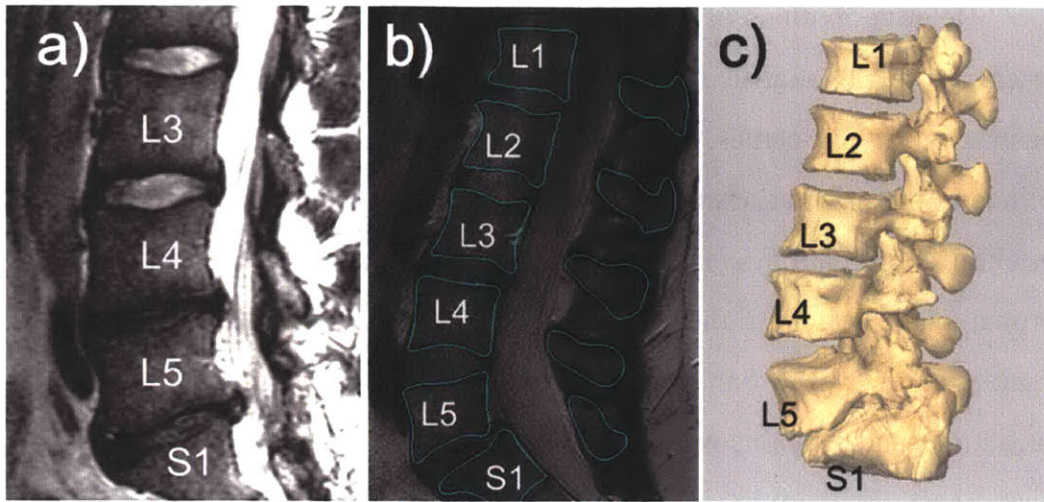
a) T2 MR image of LBP patient showing DDD at L4-5 and L5-S1. b) Digitized contours of vertebrae in the sagittal plane. c) 3D anatomic vertebral models from MRI
